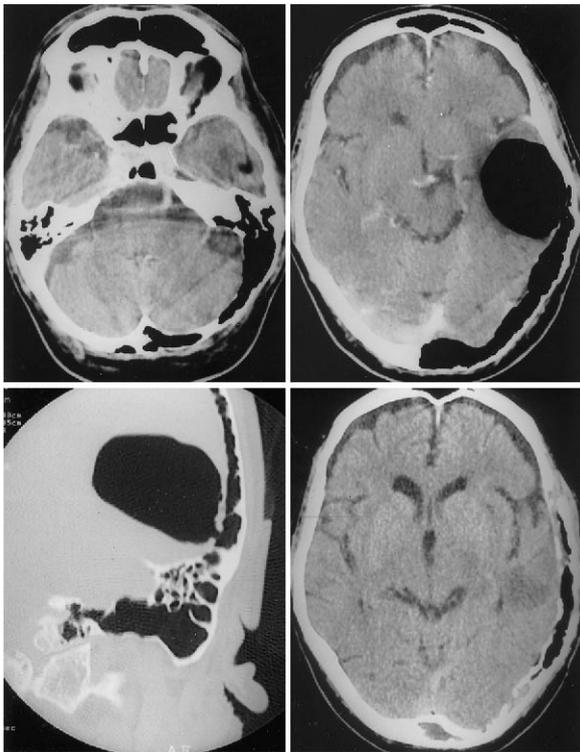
Computerized tomography (CT) scans. *Upper Left* and *Right* (axial sections) and *Lower Left* (coronal section, bone window): Preoperative enhanced CT scans showing the enlargement of the left mastoid cavity and dissection of the left occipital diploe (*upper left*), the intraaxial air-containing structure in the left temporal lobe in continuity with the enlarged aerated sinus (*upper right*) and the communication between the pneumocephalus and the left temporal diploe (*lower left*). *Lower Right*: Postoperative axial unenhanced CT scan displaying partial folding of the left intradiploic space with persistence of the air sinus and a small hypodense zone in the left posterior temporal region.
